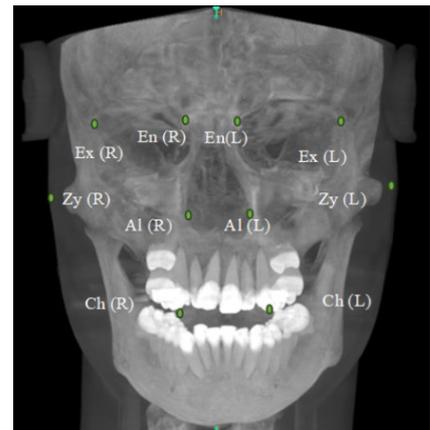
Frontal view of CBCT image. In this view, according to Kim et al (2018), the remaining 10 landmarks had been detected
